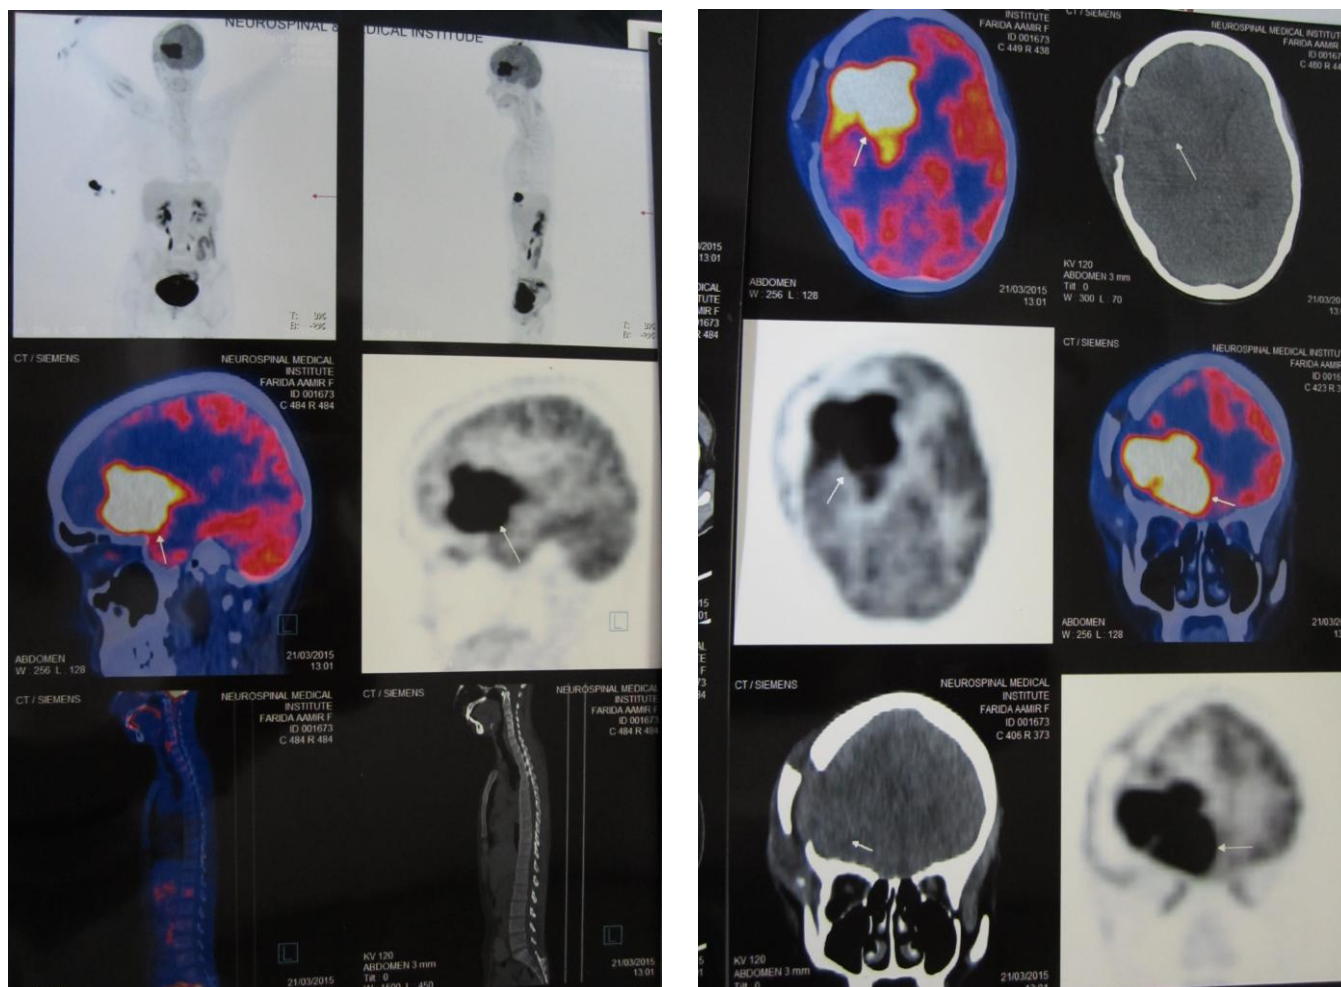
Post surgical PET / CT Scan.
